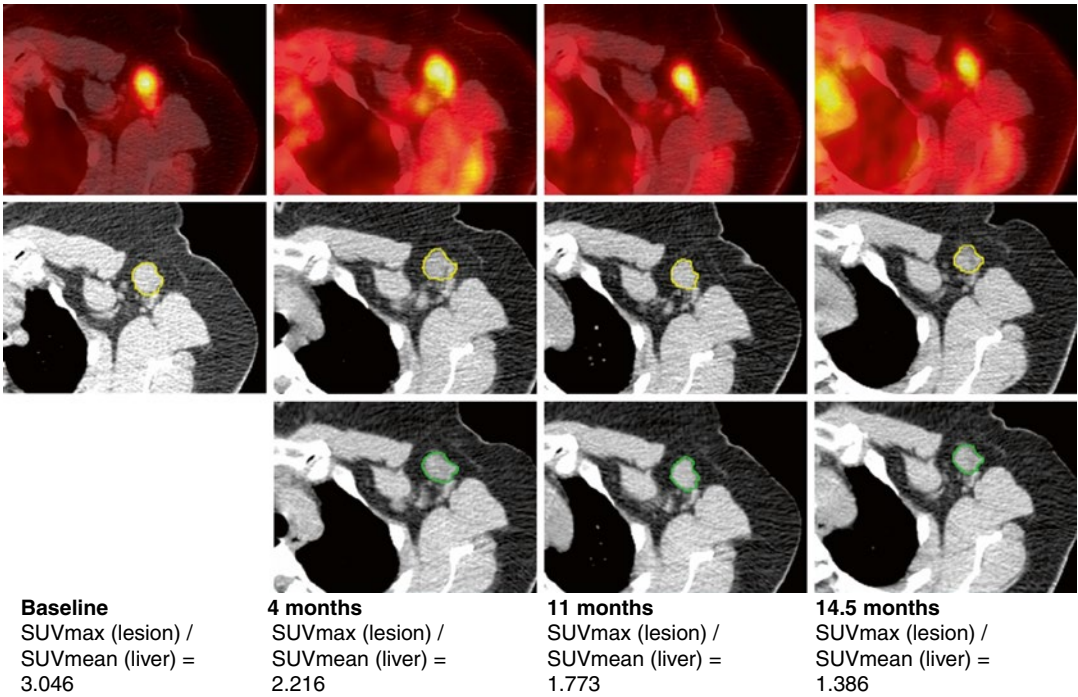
Comparison of the semiautomatic segmentation of lymph node and the automatically mapped shapes. Row 1: Fused PET/CT images at different time points; Row 2: semiautomatically segmented lymph nodes; Row
